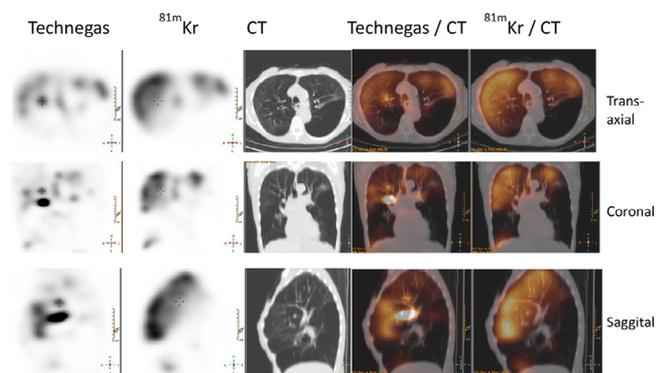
Ventilation SPECT/CT with simultaneous acquisition of Technegas and $^{81\text{m}}\text{Kr}$ -gas in a patient with severe COPD with emphysema. The krypton gas has a much more peripheral penetration and more homogenous distribution compared to Technegas, which shows several hot spots in the central airways. The ventilation is severely impaired in the lower lobes that are hyperinflated on CT. Patient has alpha-1 antitrypsin deficiency. Upper row—transaxial. Second row—coronal. Third row—saggital. Left: Technegas; left-mid: $^{81\text{m}}\text{Kr}$; center: low-dose CT; right-mid: fused Technegas/CT; right: fused $^{81\text{m}}\text{Kr}$ /CT. COPD, chronic obstructive pulmonary disease; HRCT, High-resolution CT; V/Q, ventilation-perfusion.
